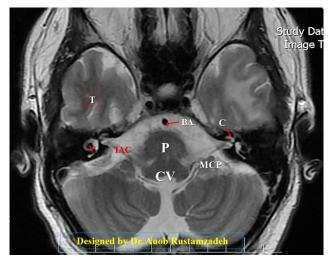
Axial view of the T2W sequence (1.5 Tesla MRI scanner) of the structure of the ear and its connections. T: temporal lobe, C: cochlea, V: vestibule, IAC: inner ear canal containing paired 7th and 8th cranial nerves, BA: basilar artery, P: pons, CV: vermis of the cerebellum that protrudes into the fourth ventricle. MCP: middle cerebellar peduncle.
